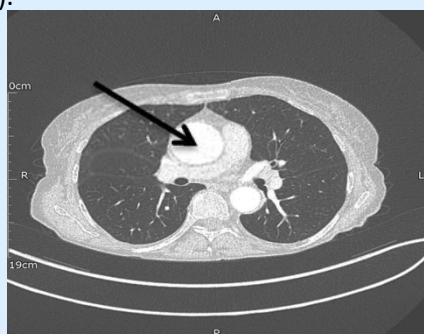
Cross-section of contrast CT showing ascending aortic aneurysm (arrow)
